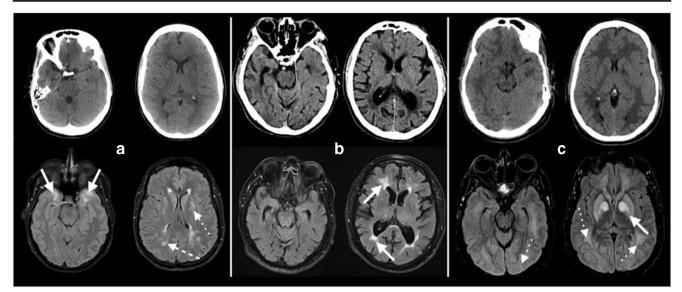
CT and MRI examples of various presentations of white matter disease. a Thirty-five-year-old woman with migraine with aura, typically peripartum since age 24, presented with acute encephalopathy that resolved after about a week. Low attenuation areas on CT (top) were better depicted on MRI (bottom), where there were multiple FLAIR hyperintensities localizing to the anterior temporal subcortical white matter (solid arrows), lenticulostriate distributions (dotted arrow), and periventricular/subcortical white matter (dashed arrow). The distribution and age were highly suggestive of CADASIL, which was confirmed with genetic testing. b Sixty-year-old male with history of hypertension and hyperlipidemia underwent workup for a transient ischemic attack. CT (top) showed volume loss and periventricular hypoattenuation. MRI
